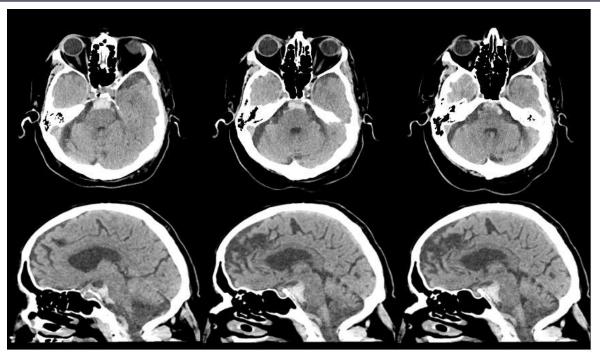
Non-Contrast CT head axial and sagittal views upon second presentation to the Emergency Department 3 days after head trauma demonstrating new perimesencephalic pontine sub-arachnoid haemorrhage with trace intraventricular extension
